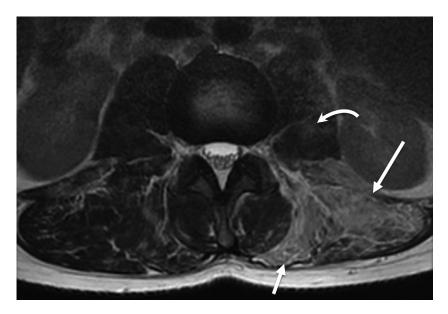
T2-weighted MRI of the lumbar spine reveals edema and atrophy most prominent within the left paraspinous muscles (straight arrows) as well as likely mild edema within the left psoas muscle (curved arrow).
